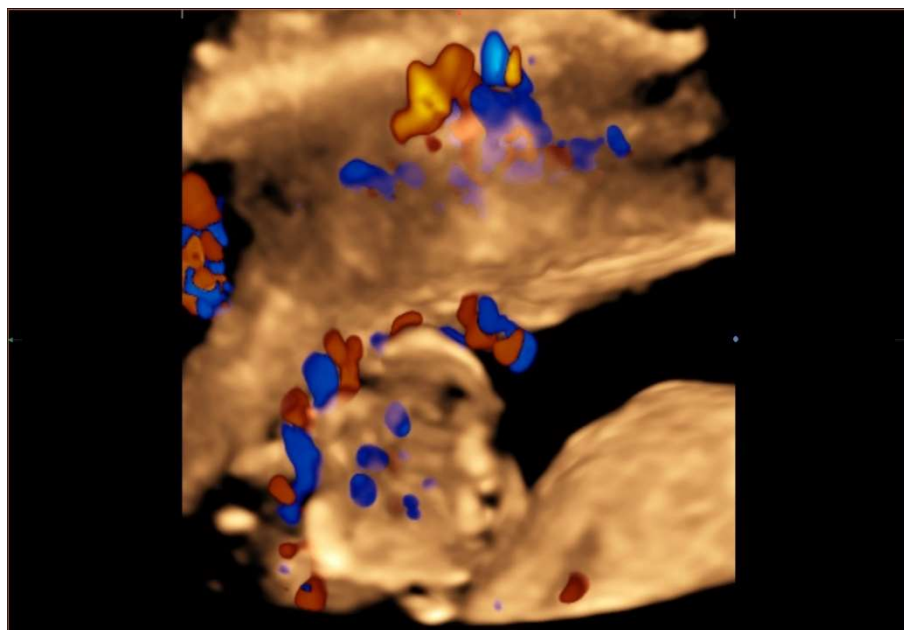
Color dopplerography. Insufficiency of remodeling of spiral arteries, which is compensated by increased blood flow resistance in pregnant group All.
